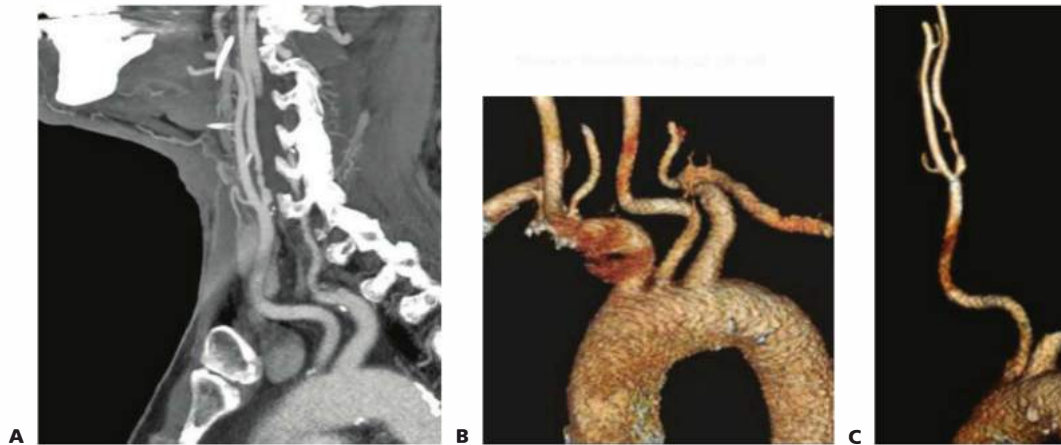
• CTA imaging of aortic arch and great vessels demonstrating a left ICA stenosis. A. Sagittal image. 3-D image reconstructions from the CTA images of the aortic arch (B) and cervical left carotid artery, demonstrating the left ICA stenosis (C).
